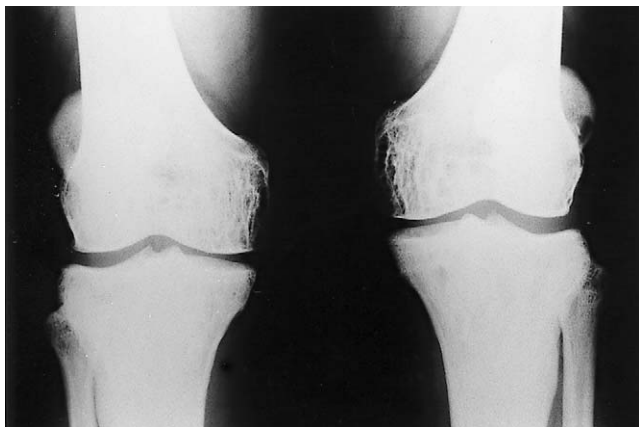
Roentgenograms of the knees show symmetrical, well-defined, non-expansile cystic lesions in the distal ends of femur and tibia of both knees.
